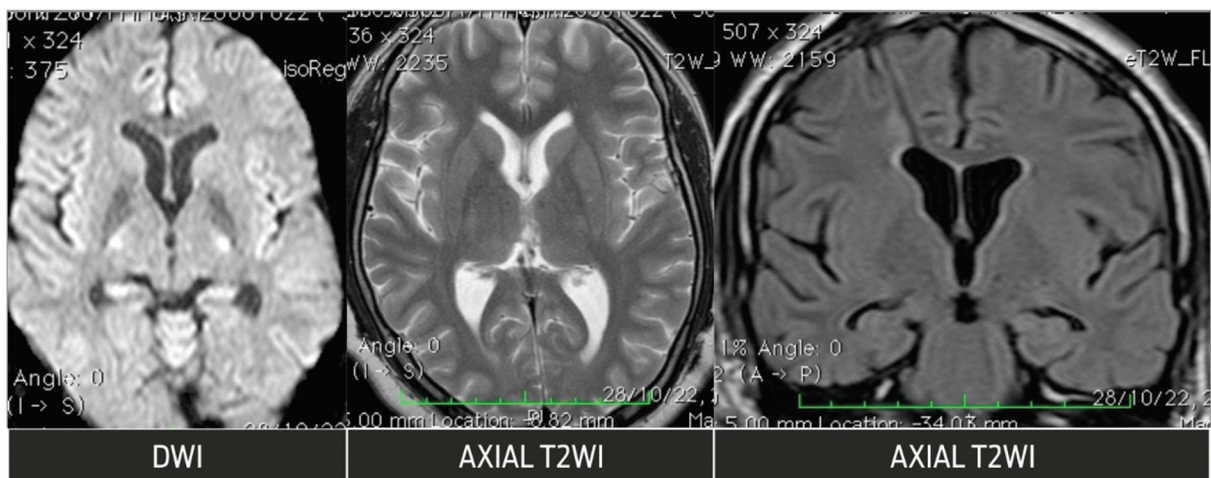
Posttreatment MRI shows complete resolution of the mass lesion in the region of the third ventricle and bilateral thalami.
